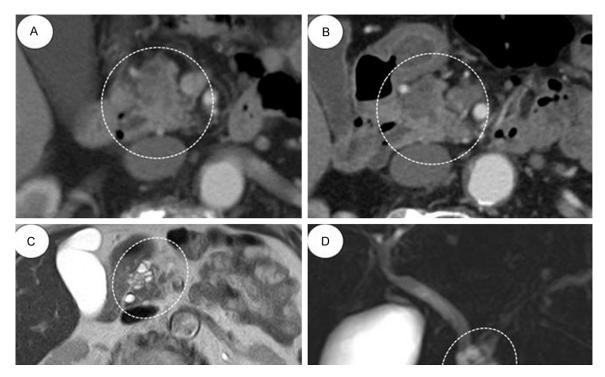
Computed tomography (CT) and magnetic resonance cholangiopancreaticography (MRCP) images of intraductal papillary mucinous neoplasms of the pancreas (IPMN) (dotted-line circle). A. At five years ago, axial contrastenhanced CT image showed a multichambered lesion located in the head and in the uncinate process of the pancreas. B. Axial contrast-enhanced CT image on the same abdominal level taken during hospitalization. C. T1-weighted image shows a hypointense mass in the uncinate process of the pancreas. D. MRCP image shows dilatation of the pancreas duct and the multilocular cystic lesion in the head of the pancreas, indicating a branch-duct type IPMN.
